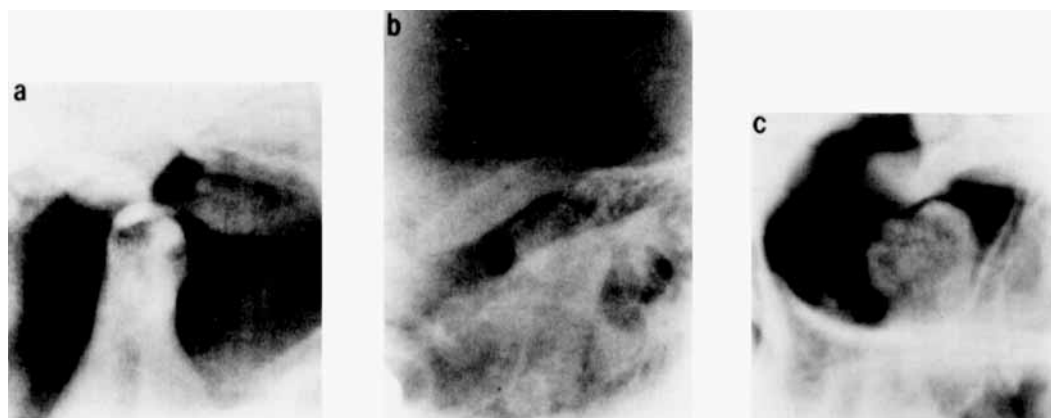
Cortical sclerosis of the condyle found simultaneously in a) an orthopantomograph, b) a transcranial radiograph, and c) a transmaxillary radiograph.
